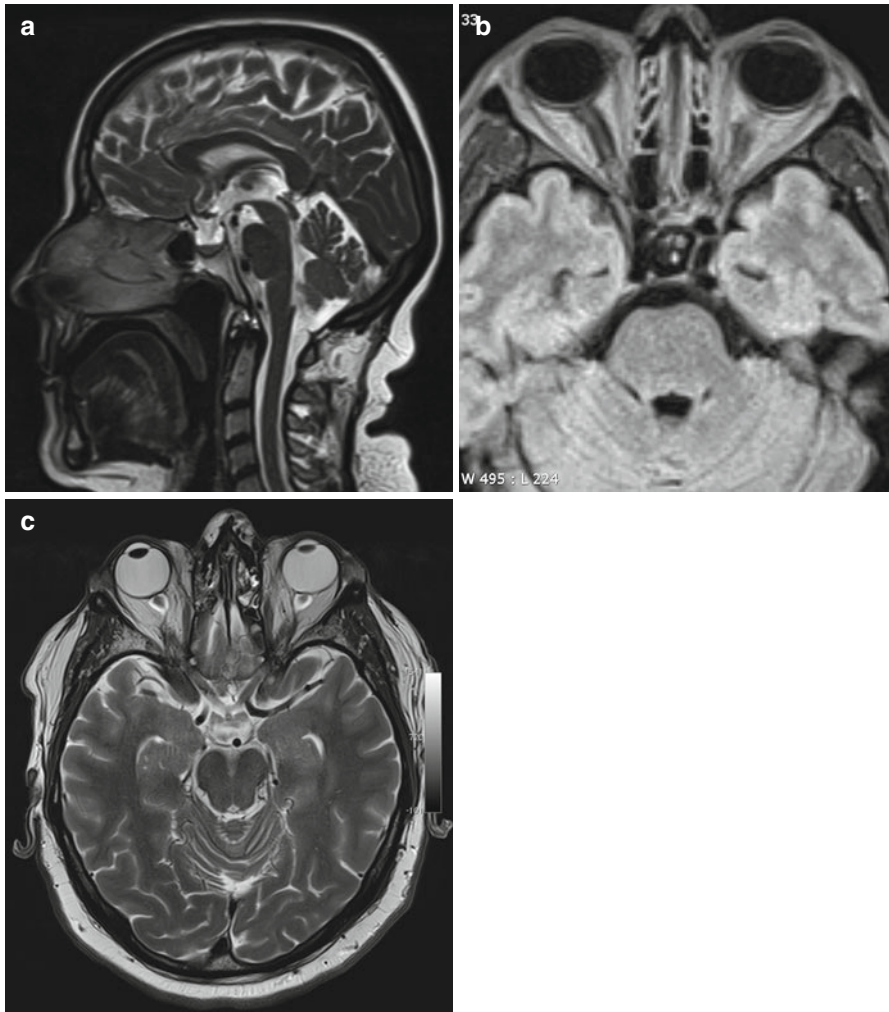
Incidental screening finding and workup at 3 T in a 32-year-old female subject with a BMI of 32 kg/m². MRI demonstrates an empty sella with only a thin strip of tissue left at the base of the sella on sagittal T2w TSE image (a). Axial T2w image shows dilated CSF spaces along both optic nerves (b). Workup, axial T2w TSE image (c), in this subject demonstrates bilateral optic disc protrusion with flattening of the posterior sclera as signs of papillary edema
